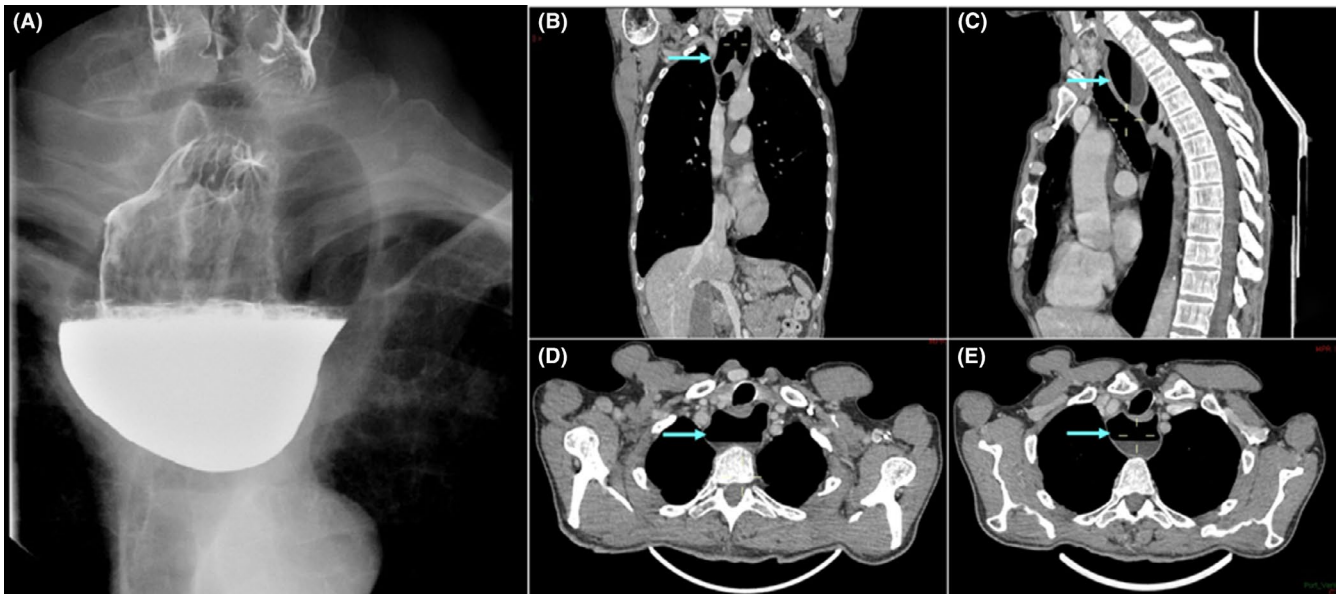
A, Pharyngeal pouch identified on barium swallow. B-E, Pharyngeal pouch on CT scan, marked by blue arrows
